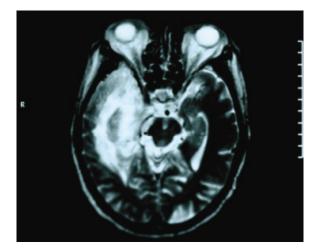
MRI demonstrated right temporal lobe signal enhancement.
